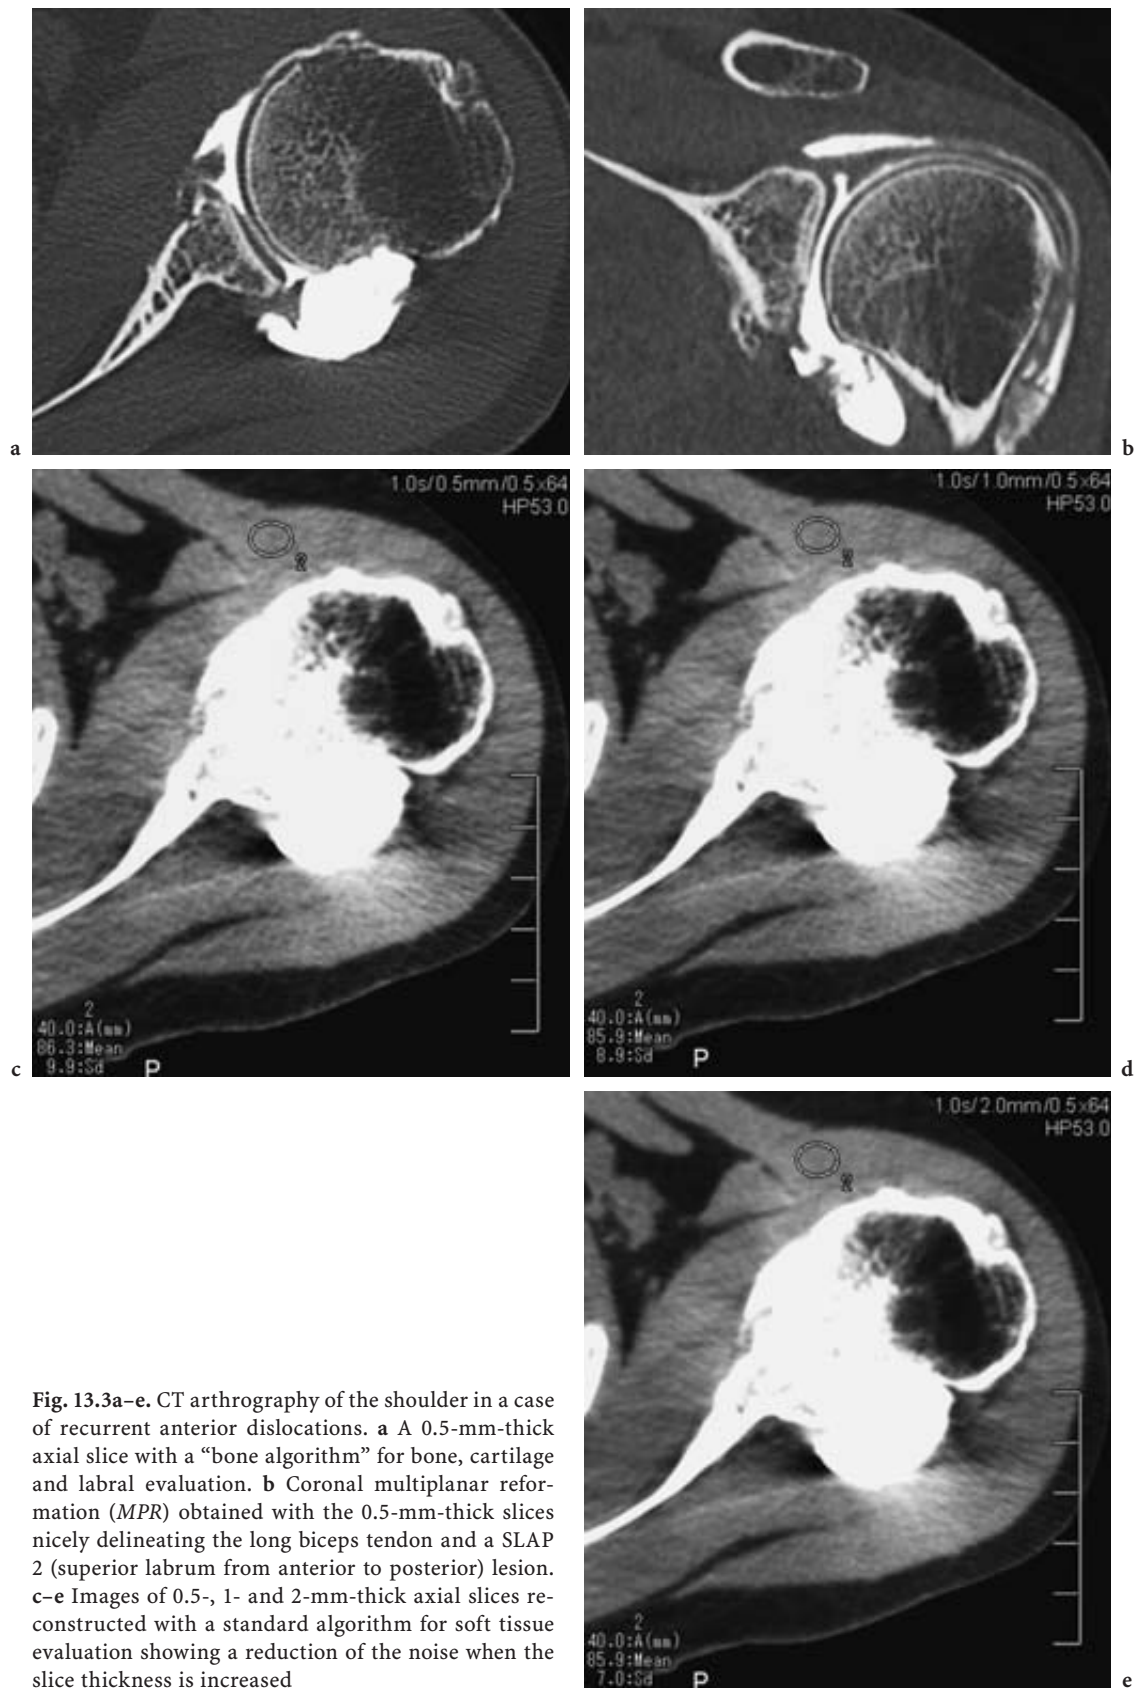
CT arthrography of the shoulder in a case of recurrent anterior dislocations. a A 0.5-mm-thick axial slice with a “bone algorithm” for bone, cartilage and labral evaluation. b Coronal multiplanar reformation (MPR) obtained with the 0.5-mm-thick slices nicely delineating the long biceps tendon and a SLAP 2 (superior labrum from anterior to posterior) lesion. c–e Images of 0.5-, 1- and 2-mm-thick axial slices reconstructed with a standard algorithm for soft tissue evaluation showing a reduction of the noise when the slice thickness is increased
